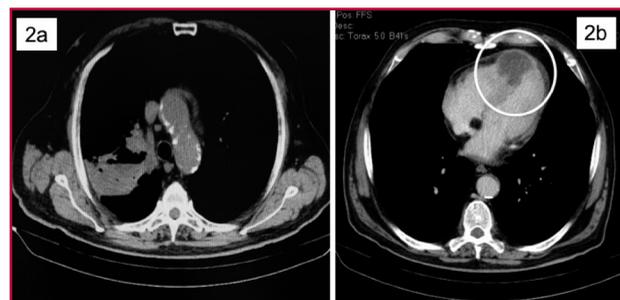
Computed tomography. 2a. Lung cancer in the right upper lobe. 2b. Myocardial interventricular septum and apex infiltration.
